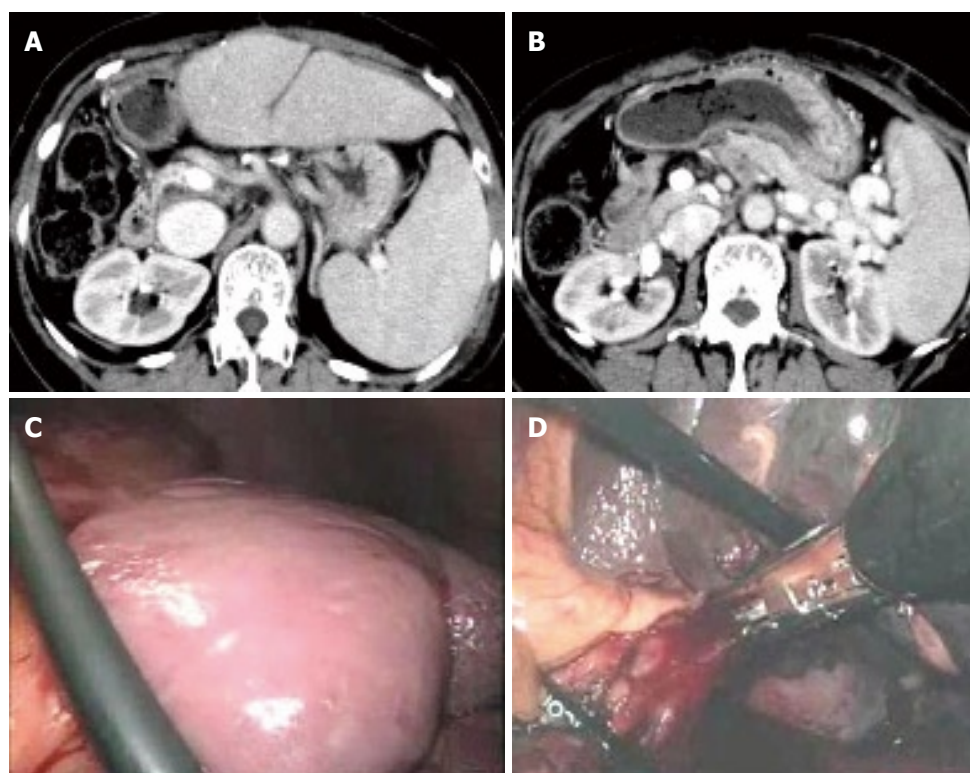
Abdominal enhanced CT showing splenomegaly with 140 mm in maximum diameter (A) and development of collateral veins around the splenic vein (B), no peritoneal adhesion to abdominal wall and around the spleen (C), and splenic hilum stapled with linear staplers (D).
